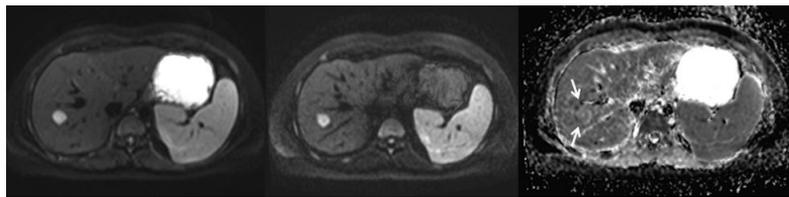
A 31-year-old female with left-side colonic carcinoma, iso-intense lesion on the ADC map seen in the right lobe (ADC value was $1.395 \times 10^{-3} \text{mm}^2/\text{s}$), which proved to be a hemangioma. (A and B) hyper-intense lesion on DWI at b value 50 and 800 respectively, (C) iso-intense lesion (arrow) on ADC map compared with liver background
